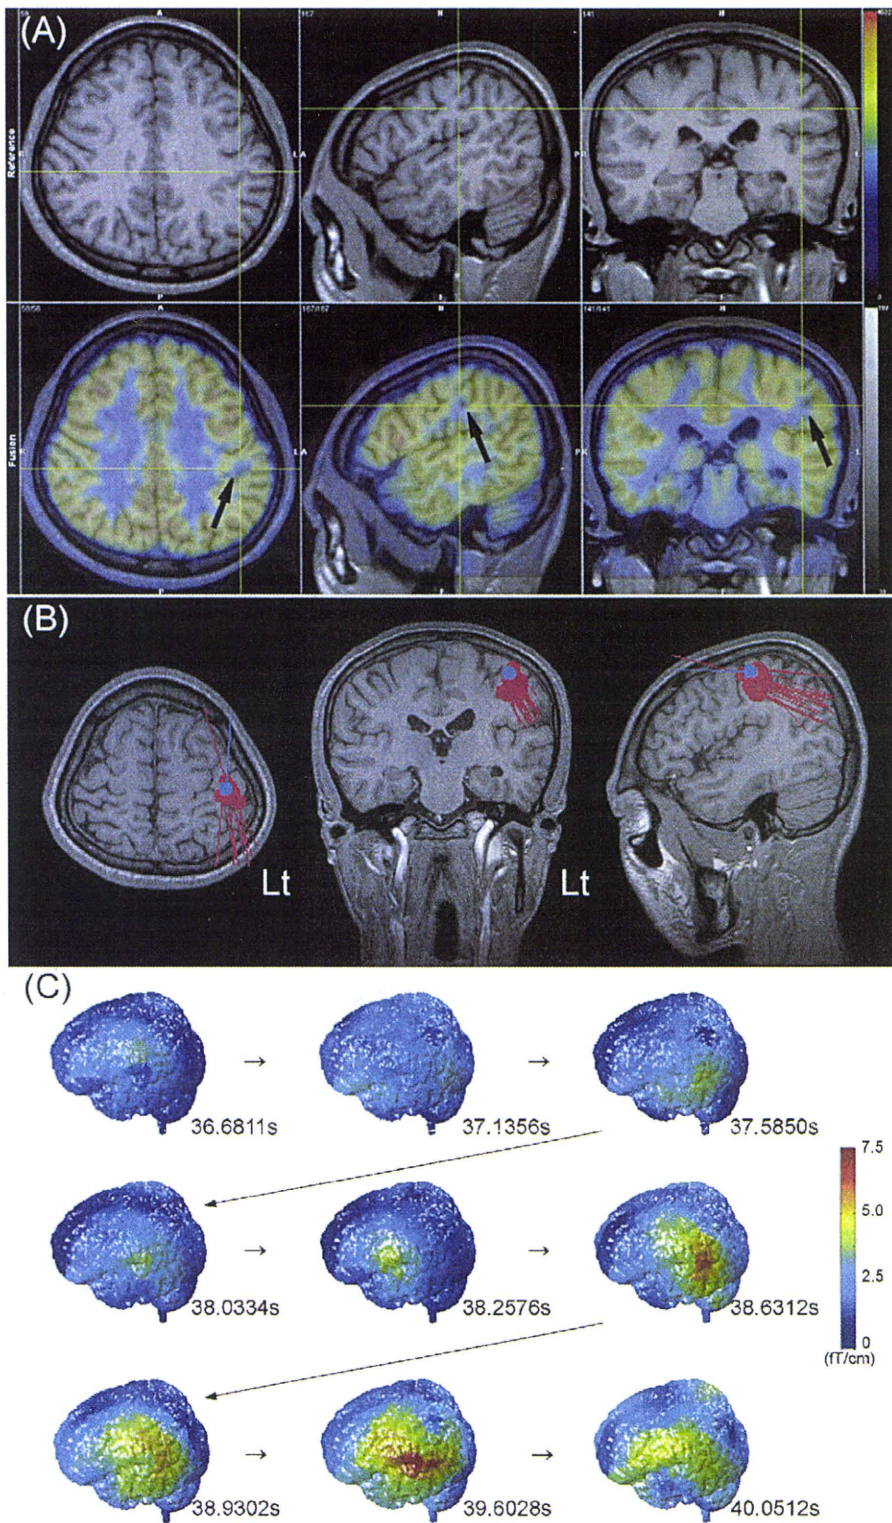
(A) Case 2 [18F]-FDG-PET: MRI (top) and [18F]-FDG-PET (bottom) showing hypometabolism of glucose consumption at the left postcentral gyrus (arrow). (B) Case 2 SDM: blue dot indicates somatosensory-evoked field and red dots indicate spike sources estimated by SDM. Those spike sources were estimated in the left postcentral gyrus. (C) Case 2 3D-MRI overlay: high-magnitude zone of 10–15 Hz oscillation was generated from the left parietal and temporal lobes and followed by propagation to the bilateral temporal and parietal lobes. Color mapping of 3D-MRI indicates the magnitudes of specific-frequency bands (10–15 Hz). (For interpretation of the references to color in this figure legend, the reader is referred to the web version of the article.)
